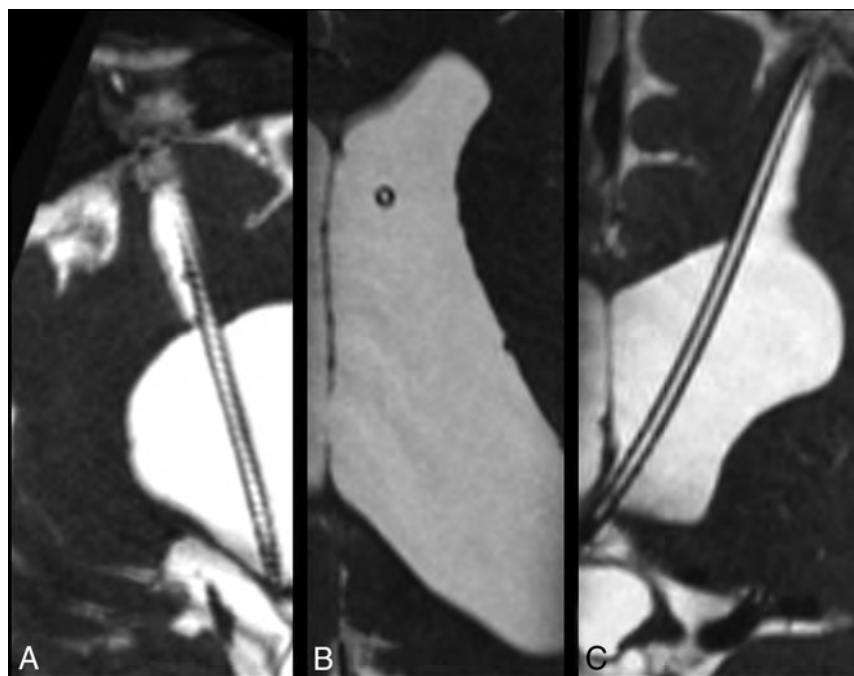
3D high-resolution isotropic CISS MR imaging sequence acquired in the sagittal plane demonstrates CSF signal throughout a patent ventriculostomy tube. Images were reconstructed post hoc in the sagittal oblique (A), axial (B), and coronal (C) planes.
